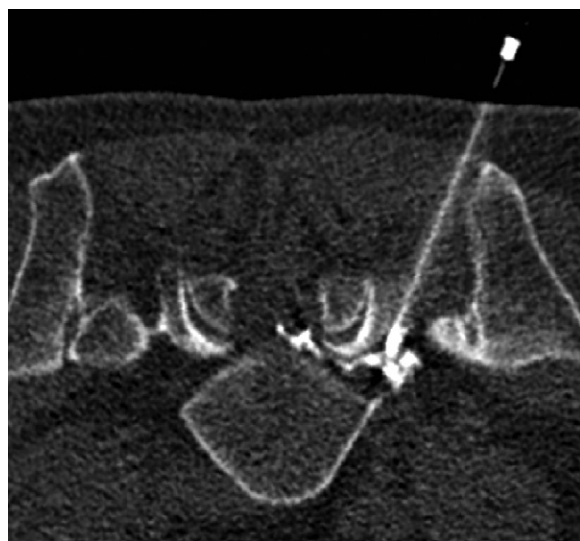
Image in 64-year-old man with radicular pain who underwent CT-guided lumbar transforaminal epidural injection. Postinjection transverse CT image shows typical contrast agent distribution along right L5 lumbar nerve root.
